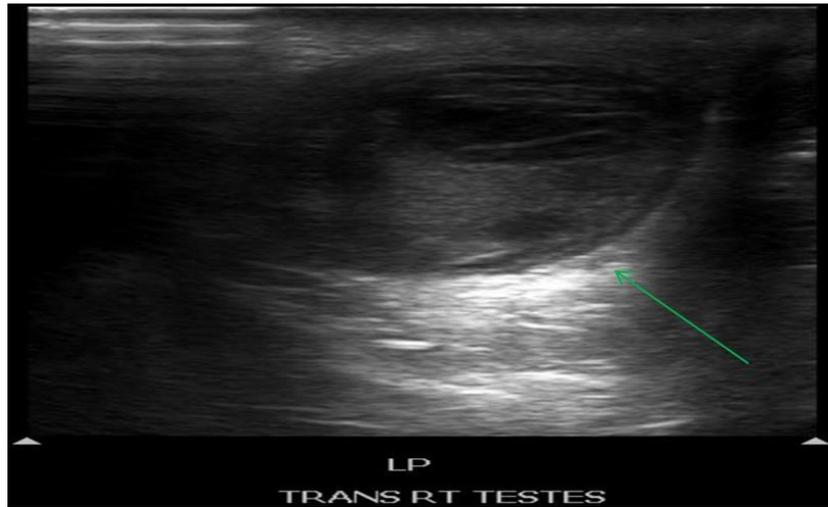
Scrotal ultrasound - Right testis transverse view. Transverse view of right testicle lower pole in the scrotum (green arrow).
